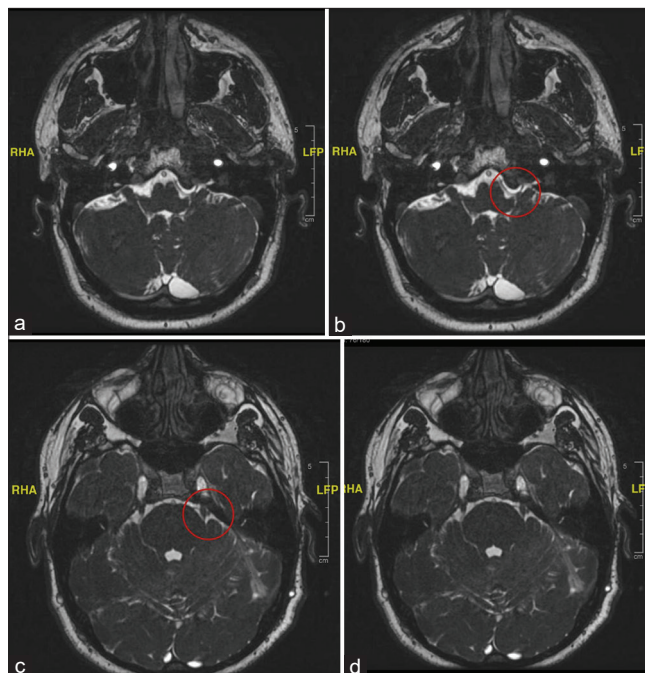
(a and b) Magnetic resonance imaging FIESTA sequence: at the level of glossopharyngeal nerve on the left side consistent with an offending loop by both SCA and AICA causing compression at root entry zone and crossing over of glossopharyngeal nerve. Here, the red circle depicts the above-mentioned findings. (c and d) Magnetic resonance imaging FIESTA sequence: at the level of Meckel cave consistent with an offending loop by both SCA and AICA causing compression at root entry zone and crossing over of trigeminal nerve. Here, the red circle depicts the above-mentioned findings. FIESTA: Fast imaging employing steady-state acquisition, SCA: Superior cerebellar artery, AICA: Anterior inferior cerebellar artery.
